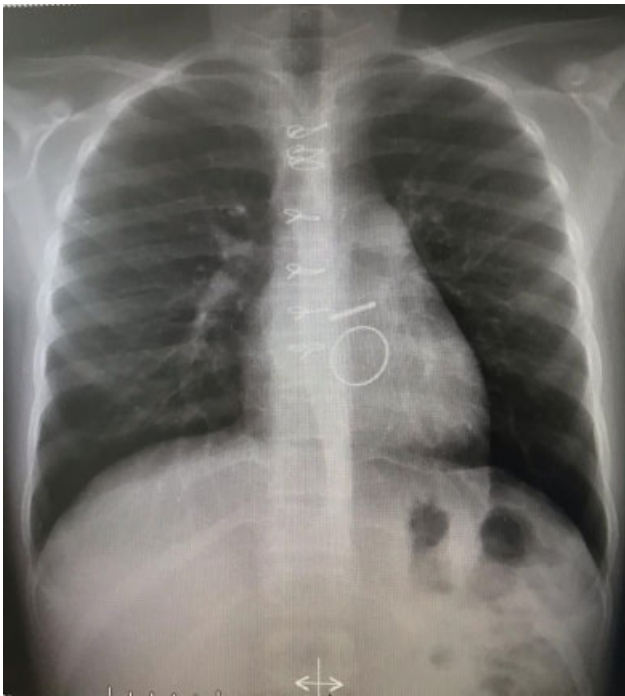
Chest X-ray showing the heart 6 months later after the surgery.
